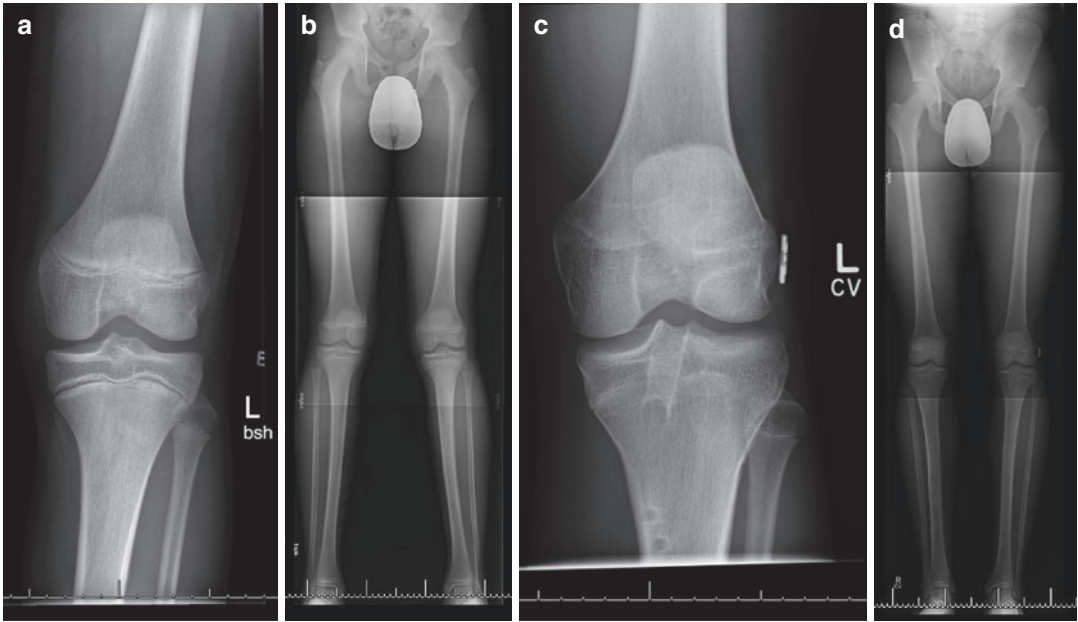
13.3 yo male with bone age of 13.6 sustained left ACL and lateral meniscal tears. Initial radiographs including AP (a) and standing lower extremity alignment films (b) are included. He underwent left knee ACL reconstruction with a hybrid femoral physeal sparing technique with hamstring autograft and lateral meniscal repair using inside-out vertical mattress sutures. He returned to sports
